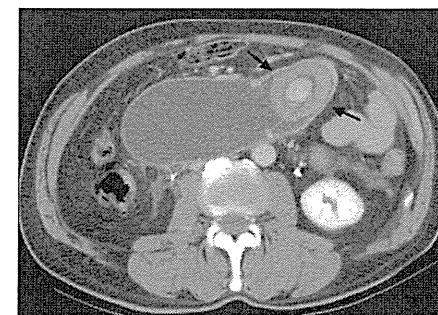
A 5x3 cm lesion with target sign in the proximal segment of afferent loop was identified on CT images (arrows).
